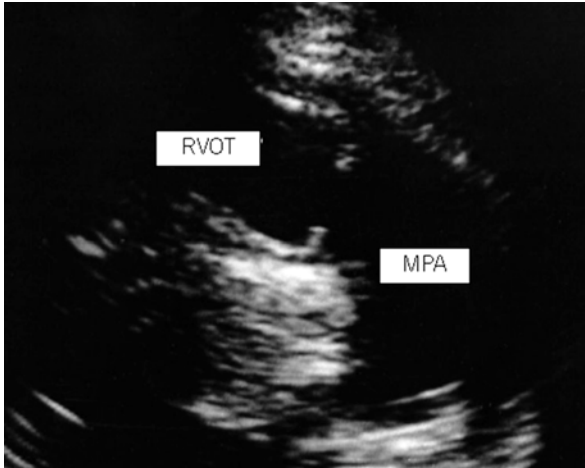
Pulmonic stenosis echocardiogram: echocardiogram showing valvular doming, and thickened pulmonic valve
